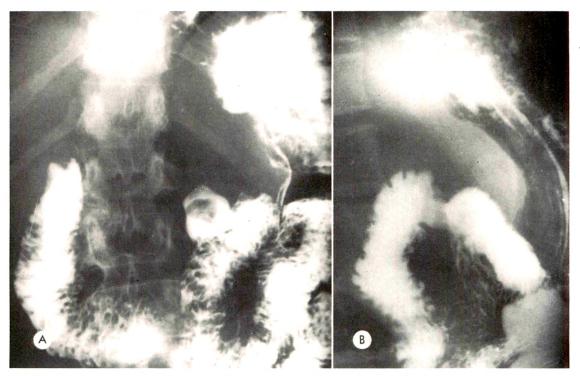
Carcinoma of the body and tail of the pancreas with extension into the uncinate process. (A) Supine roentgenogram. A small nodular type defect is present at the junction of the 2nd and 3rd portion of the duodenum in the region of the uncinate process. The folds are distorted and irregular. A ring shaped calcification just above the duodenum represents a hepatic artery aneurysm. It could easily be mistaken for a gallstone. The defect was not well documented in the prone roentgenogram. The supine study in some cases may be the better for delineating the tumor when it extends posteriorly (see B). (B) The retrogastric space is enlarged with an indentation characteristic of the body of the pancreas. Note the anterior deviation of the distal descending duodenum even though the retroduodenal space is not enlarged. In addition, the thickened rigid divergent folds in the region of the uncinate process are prominent. The postbulbar indentation is due to a dilated common duct.
